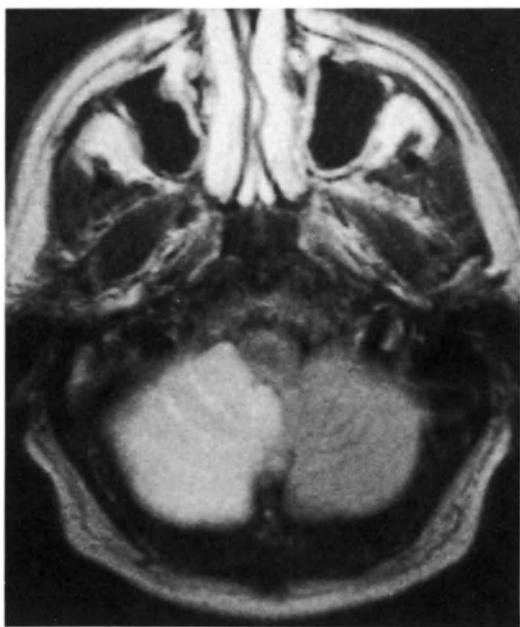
Axial MRI study ( $T_2$ -weighted) shows high signal from right cerebellar infarct (PICA).
